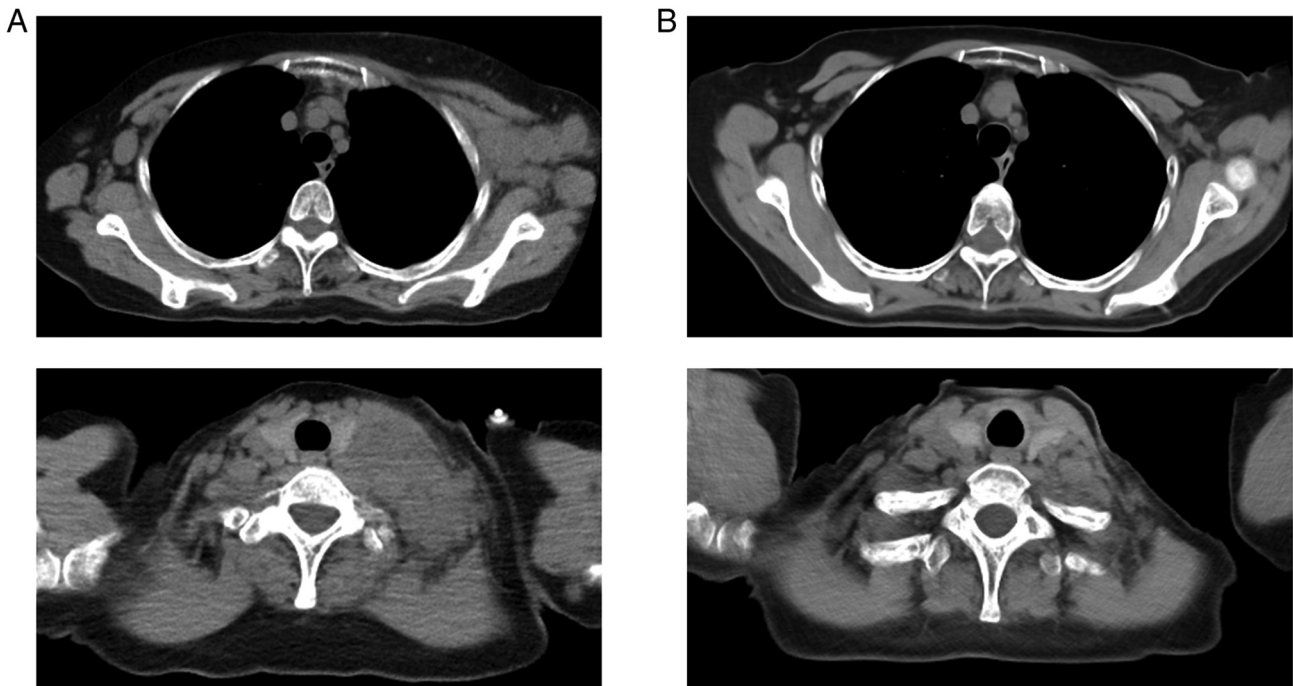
Comparison of non-contrast CT before and after therapy. (A) Axial baseline CT and (B) follow-up axial CT after three cycles of therapy. The upper panels show the left axillary lymph node region, and the lower panels show the left cervical lymph node region. Two left axillary lymph nodes decreased from 26 and 21 mm at baseline to 0 and 0 mm post-treatment, respectively, while the left cervical lymph node decreased from 25 mm to 0 mm, demonstrating a complete response in both regions. CT, computed tomography.
